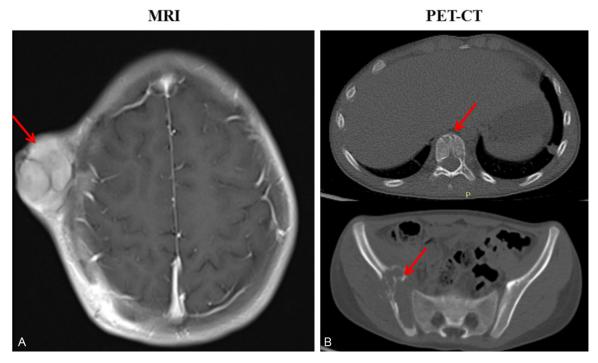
Radiological pictures of the lesion in case 2. A: Magnetic resonance imaging (MRI) revealed a large contrast-enhancing mass in the right frontal temporal region and multiple abnormal signals in the surrounding neck and ear soft tissues. Hemorrhage and necrosis in lesions were also evident (red arrow). B: PET/CT showed systemic multiple bone destruction with active metabolism, including vertebral body and pelvis (red arrow).
